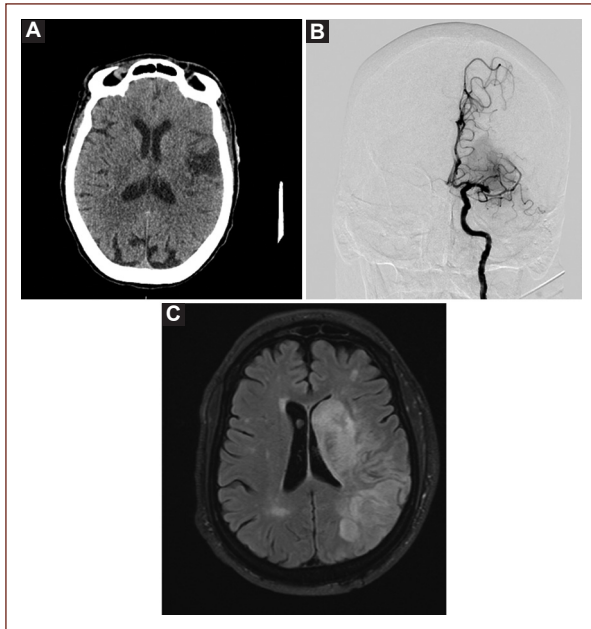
Imaging patterns in AF-related stroke. A: A non-contrast head CT in a 85-year-old woman presenting with aphasia and right-sided weakness, demonstrating a wedge-shaped infarct in the left middle cerebral artery distribution. B: The digital subtraction angiogram for the same patient demonstrating an acute left middle cerebral artery occlusion. C: A T2 FLAIR MRI in a 58-year-old man with new onset AF and a large left hemispheric acute infarct, as well as evidence of hyperintensities in bilateral hemispheres suggestive of small vessel disease.
